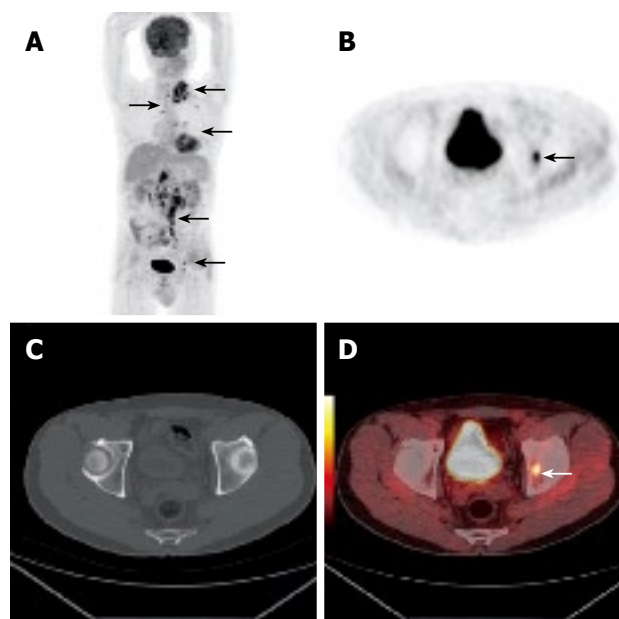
A 67-year-old man underwent PET/CT due to clinically suspected disease recurrence in supraclavicular lymph nodes after his gastric cancer resection which was performed 2 mo previously. Whole body PET projection image showed retroperitoneal and supraclavicular metastatic lymph nodes and bone metastasis. (arrows, A, B and D). Axial CT failed to reveal early bone metastasis (C).
